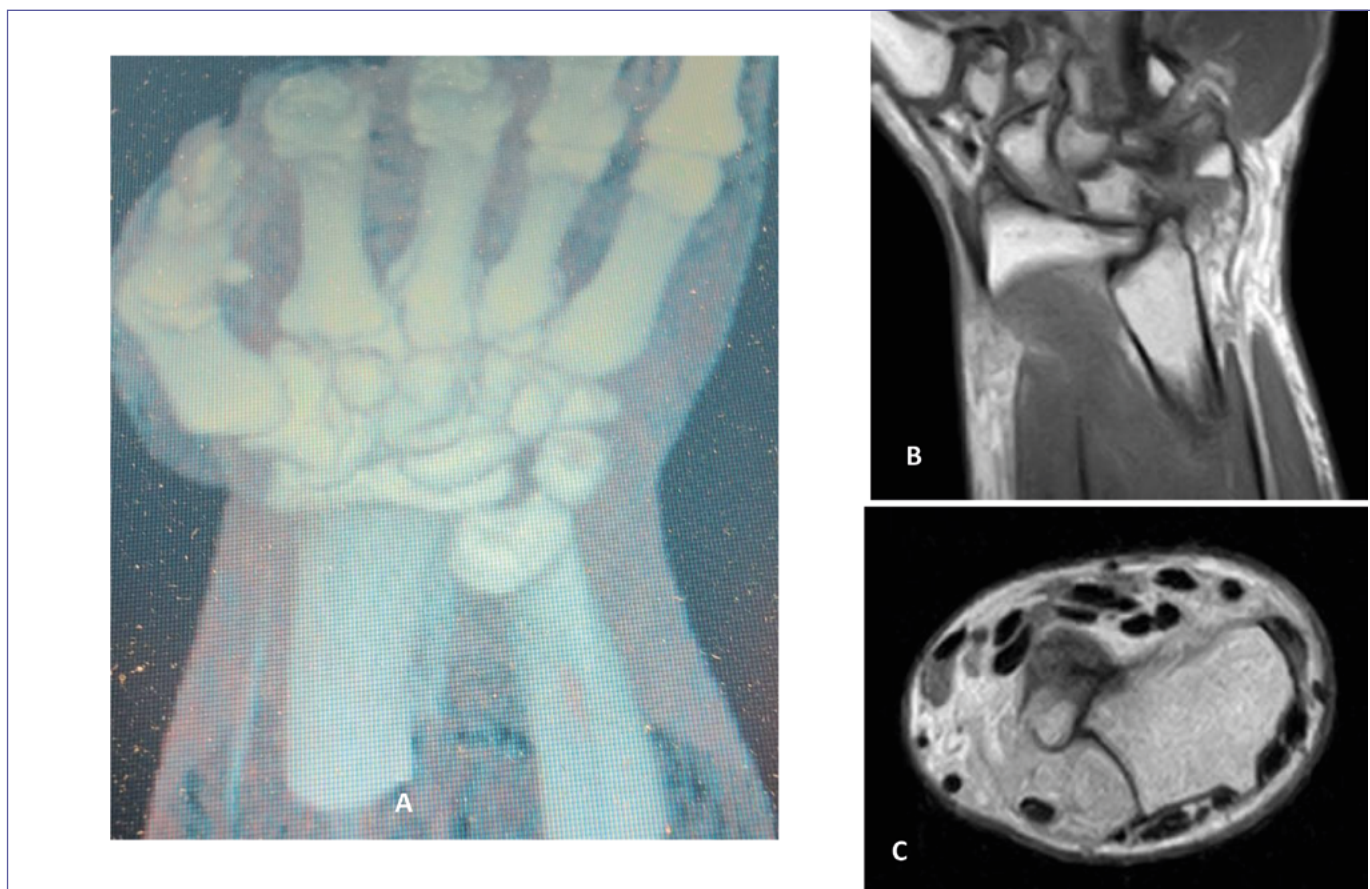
A) Volar view of a 3D CT scan; B) coronal view and C) axial view of a MRI of the wrist, showing a locked volar dislocation of the ulnar head engaged with the volar corner of the sigmoid notch.
